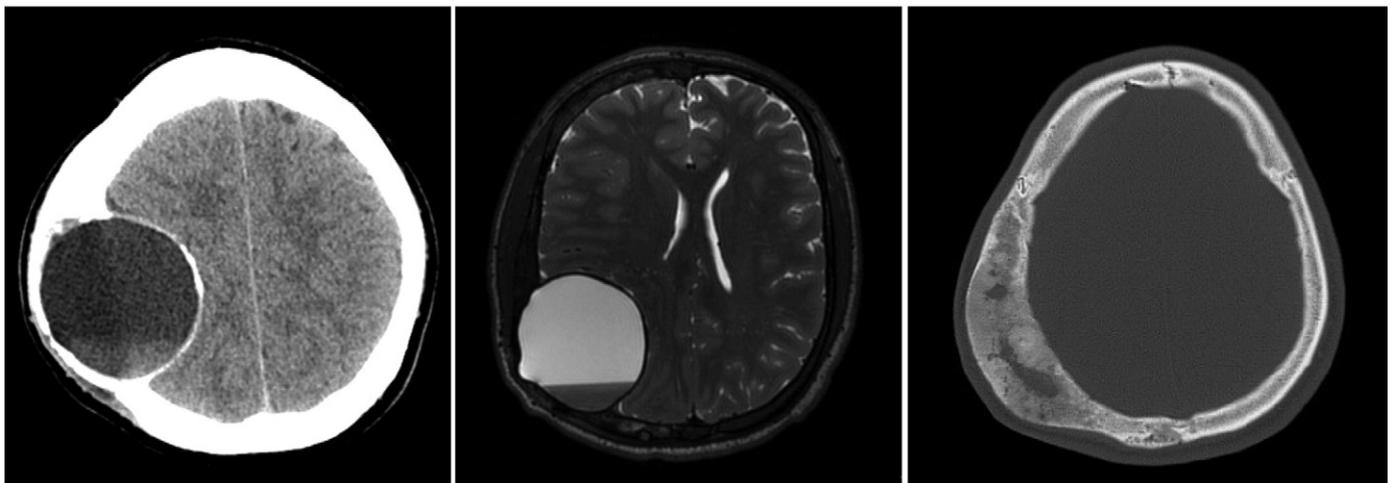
A large aneurysmal bone cyst is demonstrated on axial non-contrast CT scan (left panel) and T2-weighted axial MRI (middle panel) with compression of the parietal lobe and significant midline shift. CT bone window shows aneurysmal bone cyst is located within area of fibrous dysplasia (right panel).
